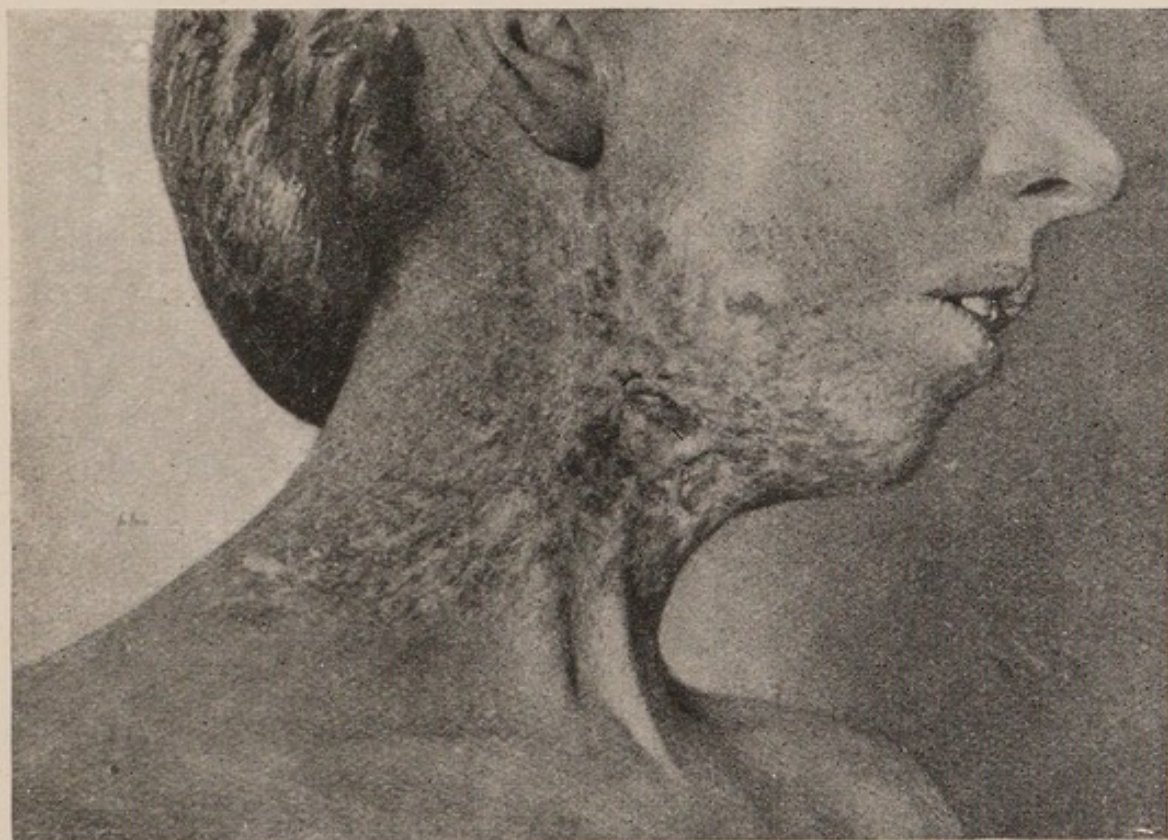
Chronic X-ray burn, showing atrophic skin, superficial ulceration, and telangiectases.
